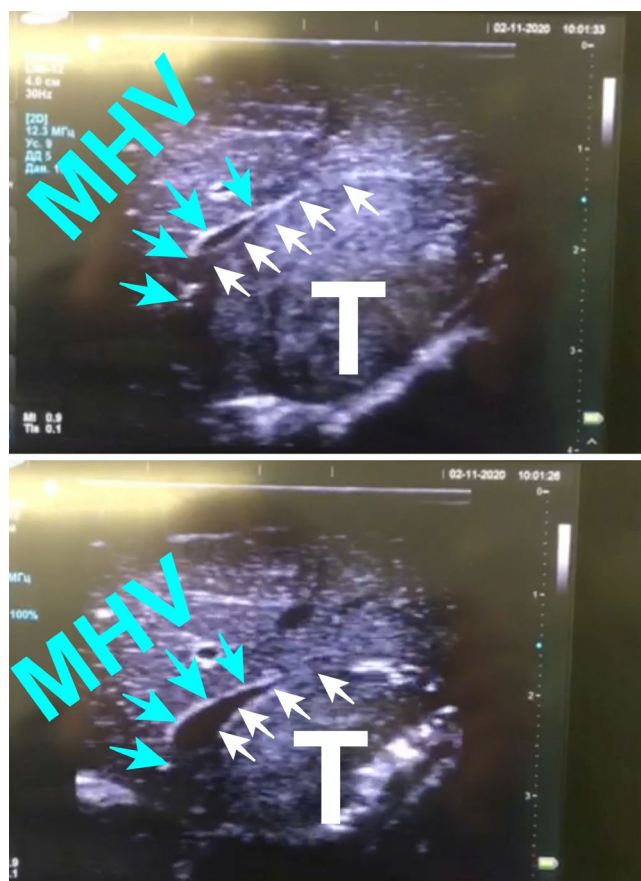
Picture and ultrasound data of patient S. MHV, middle hepatic vein without signs of invasion, contacting at a distance of 3 cm on the $\leq \frac{1}{2}$ semicircle to the metastatic lesion (blue arrows); T, metastatic lesion with vascular contact (white arrows)
